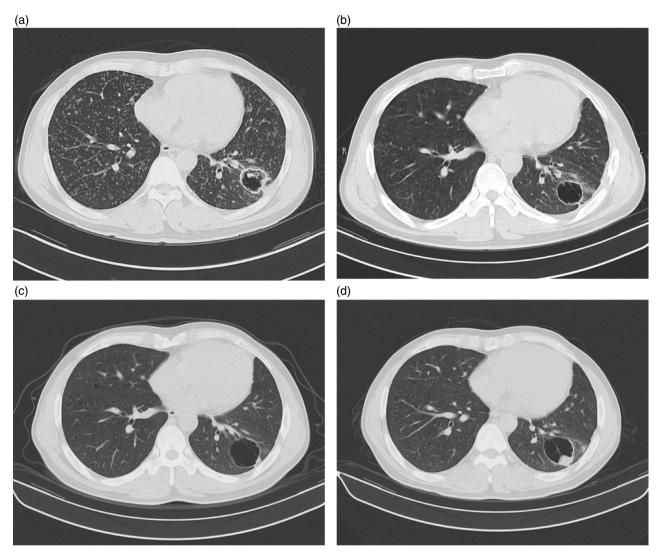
The four computed tomography (CT) pictures showed a variation of a thin-walled cystic lung cancer of left lower lobe. (a) CT revealed a thin-walled cystic lesion in left lower lobe with intrapulmonary metastasis in bilateral lung. (b) After taking EGFR-TKI treatment for 2 months, intrapulmonary metastasis disappeared and wall of cyst became smooth and regular. (c) CT scan after EGFR-TKI treatment was administered for 6 months. (d) Tumor progressing after target therapy was stopped for 7 months.
